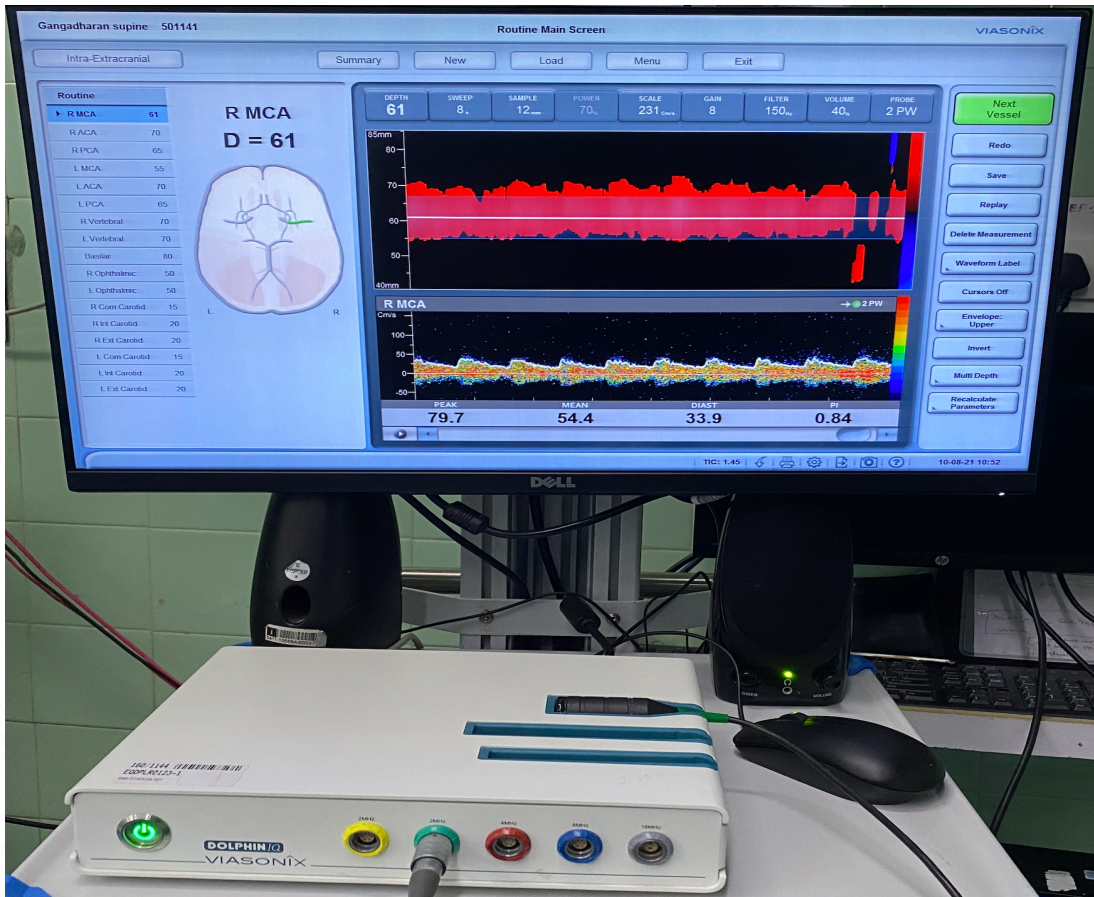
The Transcranial Doppler machine and the probe used in our study.
